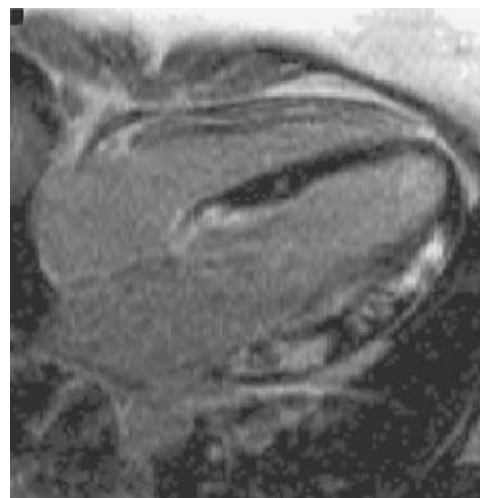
Cardiac sarcoidosis. Cardiac magnetic resonance image with late gadolinium enhancement showing patchy mid-wall patterns affecting the lateral wall at the base and apex in the four-chamber view. (From O’Hanlon R, Pennell DJ. Cardiovascular magnetic resonance in the evaluation of hypertrophic and infiltrative cardiomyopathies. *Heart Fail Clin.* 2009;5:369-387, with permission.)
